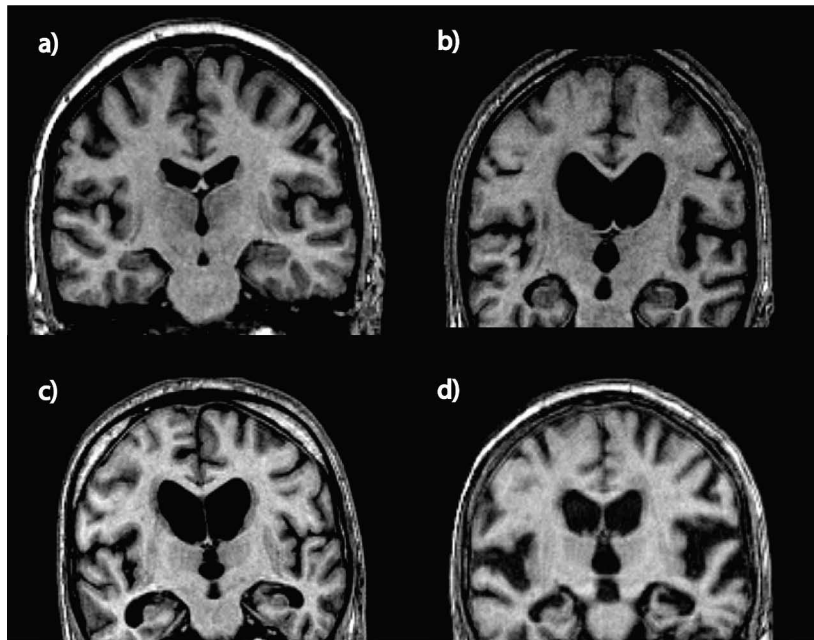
Coronal sections of T1 weighted MRI images depicting a healthy elderly subject (a) and patients with AD with mild (b), moderate (c) and severe (d) hippocampal atrophy. The images are courtesy of Timo Erkinjuntti.
